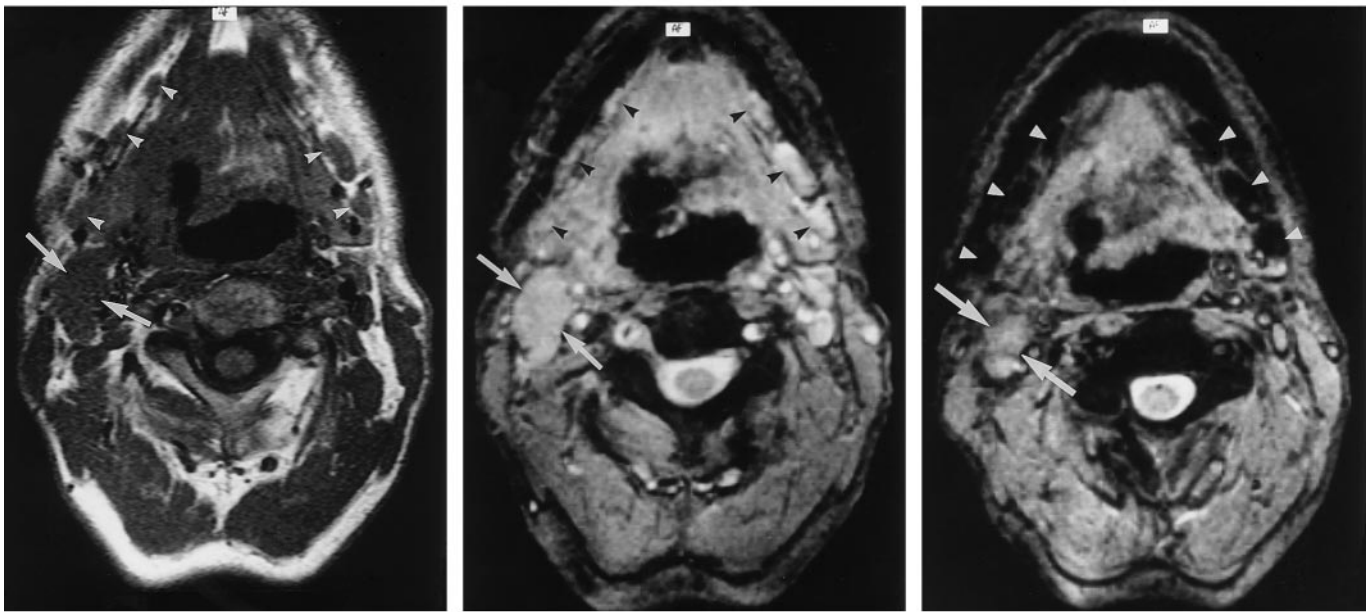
Tonsillar carcinoma and benign and malignant lymph nodes on both sides. (a) Transverse nonenhanced T1-weighted SE image (500/15) with lymph nodes in level I (arrowheads) on both sides and in level II (arrows) on the right side. (b) Transverse nonenhanced T2-weighted GRE image (500/15, 15° flip angle) demonstrates the lymph nodes in level I (arrowheads) on both sides and in level II (arrows) on the right side, with hyperintense signal. (c) Transverse SPIO-enhanced T2-weighted GRE image (500/15, 15° flip angle) obtained 30 hours after infusion of contrast material demonstrates no SI decrease in the lymph node in level II (arrows) on the right side, which represents lymph node metastasis. Note the SI decrease in the lymph nodes in level I (arrowheads) on both sides; this represents reactive lymph nodes.
